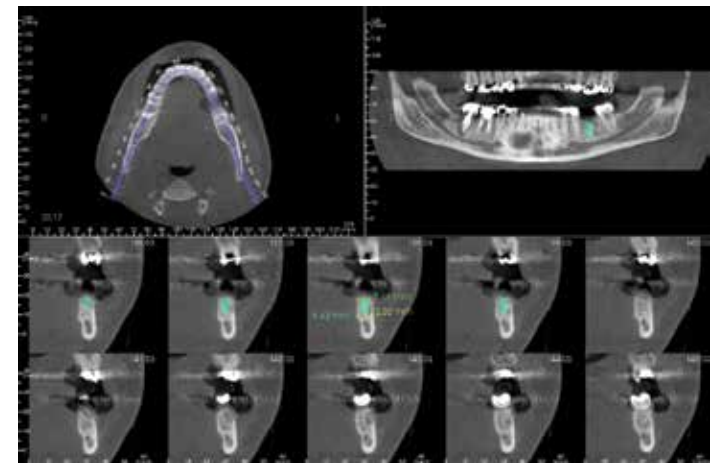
Traditional implant planning techniques involve a 2D interpretation of the 3D CBCT scan
